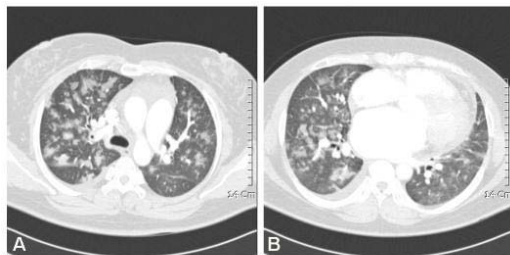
Chest CT shows multiple nonsegmental ground glass opacities on both lung fields (A : upper and mid lobe of lung, B : mid and lower lobe of lung)
